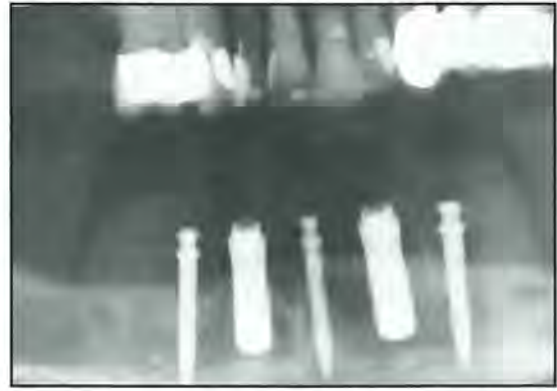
Postoperative radiograph obtained 6 weeks following implant placement confirmed implant stabilization and integration.
